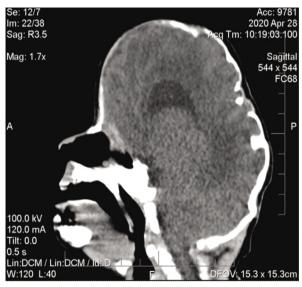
Head CT scan (sagittal midline section)
